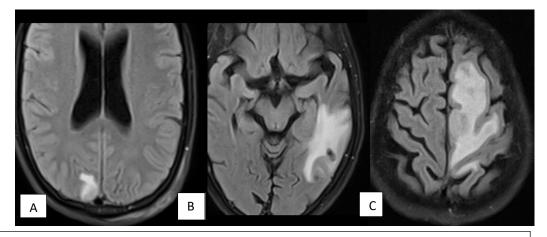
MRI FLAIR images showing Degrees of edema surrounding lesions
